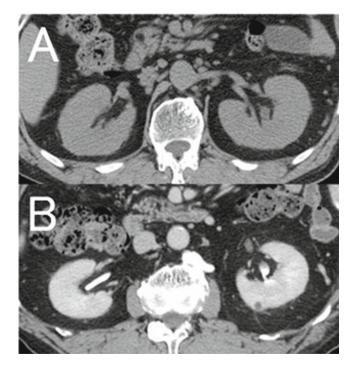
Changes in computed tomography (CT) findings after corticosteroid therapy. Diffuse bilateral renal swelling before therapy (a) was improved with relatively uniform contrast enhancement 1 month after therapy (b)
